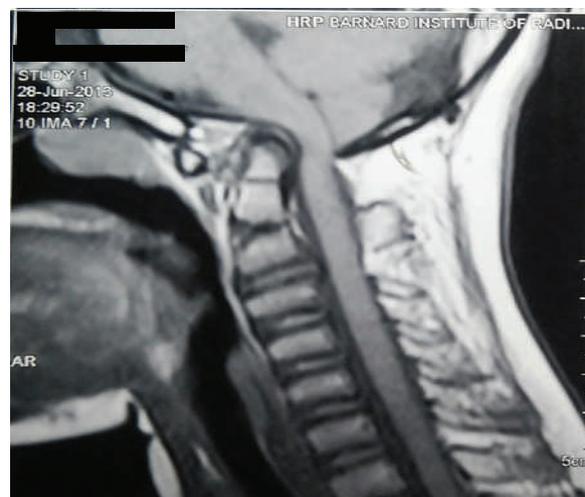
MRI showing enlarged odontoid compressing the spinal cord
